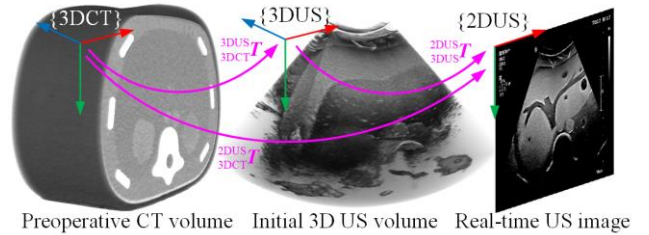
Intraoperative 2D US - preoperative 3D CT registration.
